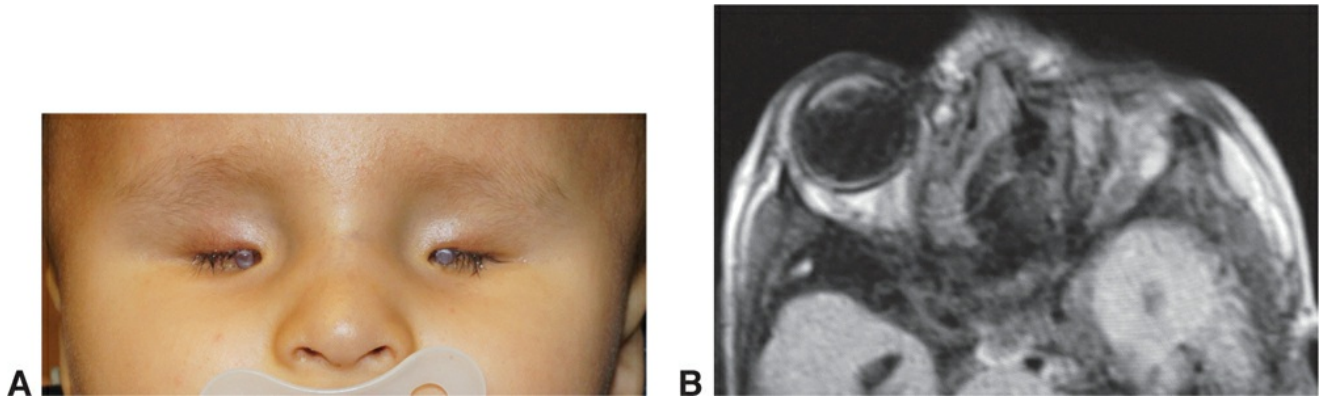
A, Anophthalmia, both eyes. B, Magnetic resonance image from a patient with unilateral anophthalmia shows absence of ocular structures. (Part A courtesy of Steven Couch, MD; part B courtesy of Alice Bashinsky, MD.)
